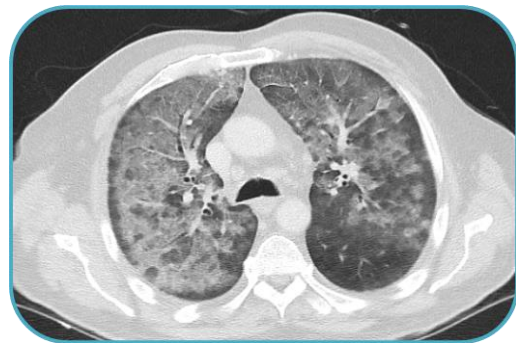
CT chest showing diffuse alveolar infiltrates
